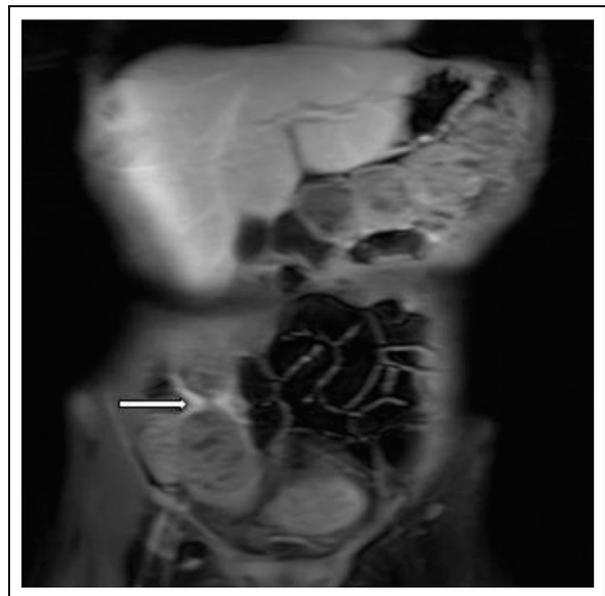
Magnetic resonance image of the abdomen showing stricture of the bowel with prestricture and poststricture bowel dilation in a patient with Crohn disease.
